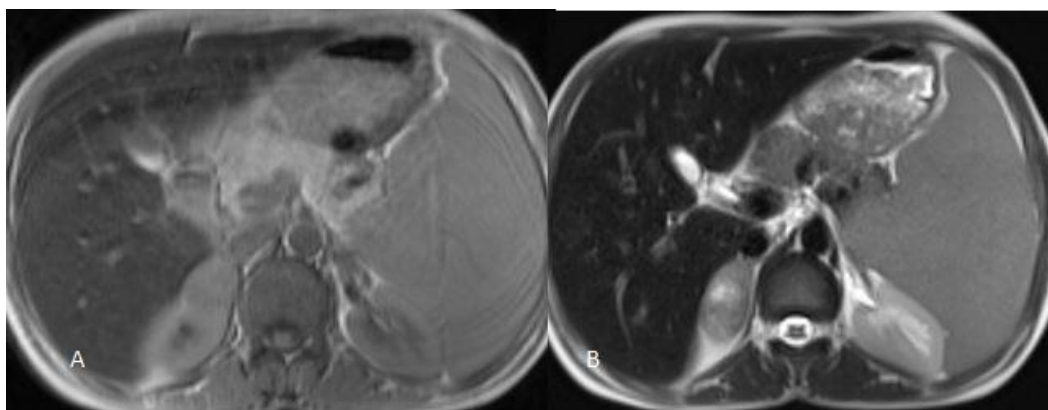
A- MRI Abdomen (Axial T1), B-(Axial T2)- showing well defined right suprarenal mass appearing hypointense in both T1 and T2WI.
